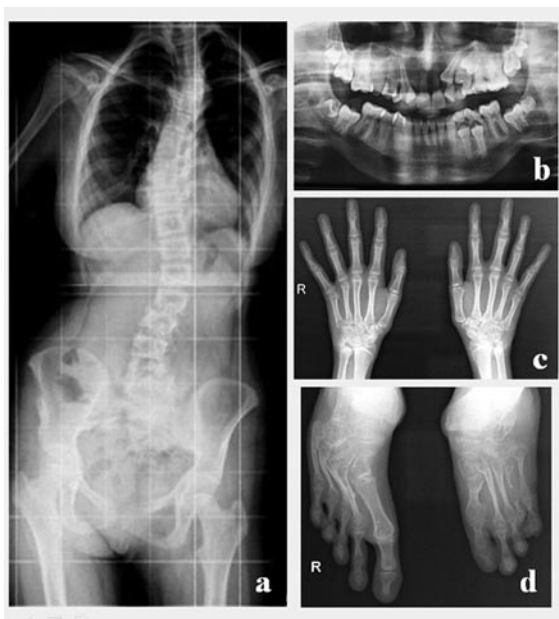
Plain radiographs show scoliosis (A), arachnodactyly (C) and equinovarus deformity (D); Dental radiograph demonstrating malocclusion and crowded teeth (B) of the patient at 13 years of age.
